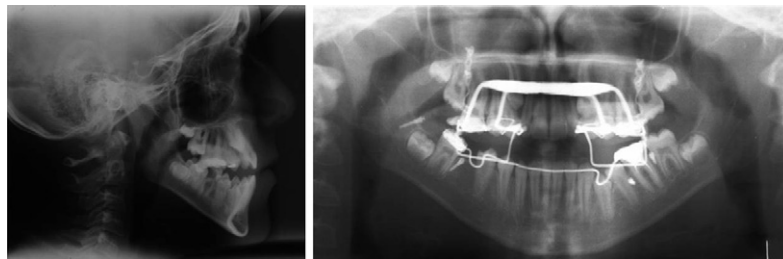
Initial cephalometric and progress panoramic radiographs of case 1.
